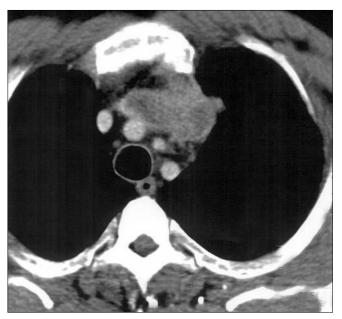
Chest CT scan-mediastinal mass
